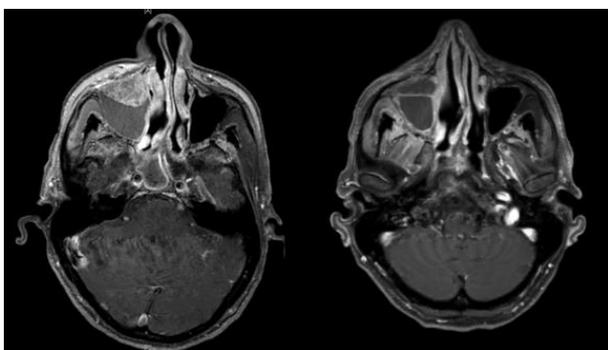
MRI with contrast prior to radiation (left) and 6 months post radiation (right).
